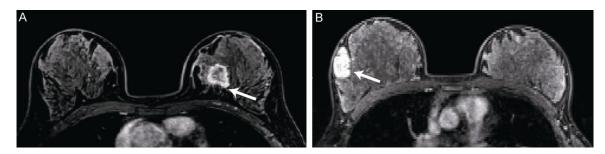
DCE-MRI images of breast tumors. A: Infiltrating ductal carcinoma of the left breast, with quasi-circular nodules and circular enhancement; B: Fibrotic adenoma of the right breast, with oval-shaped, smooth edges. The arrow points to a breast tumor.
